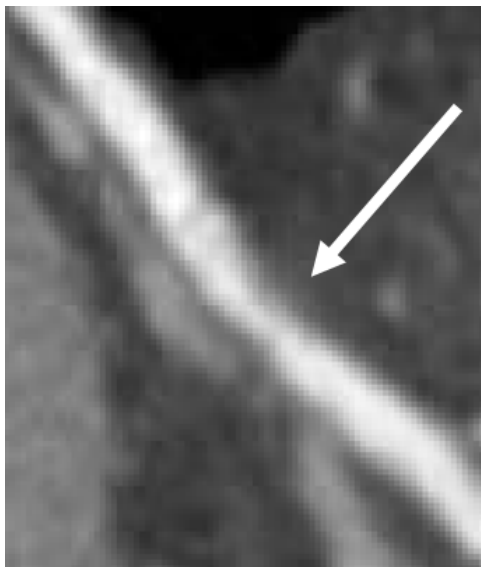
Appearance of an artery stenosis (narrowing) in a CTA image: decreased diameter of bright lumen reveals the presence of soft-density plaque on the inner walls of the vessel.
